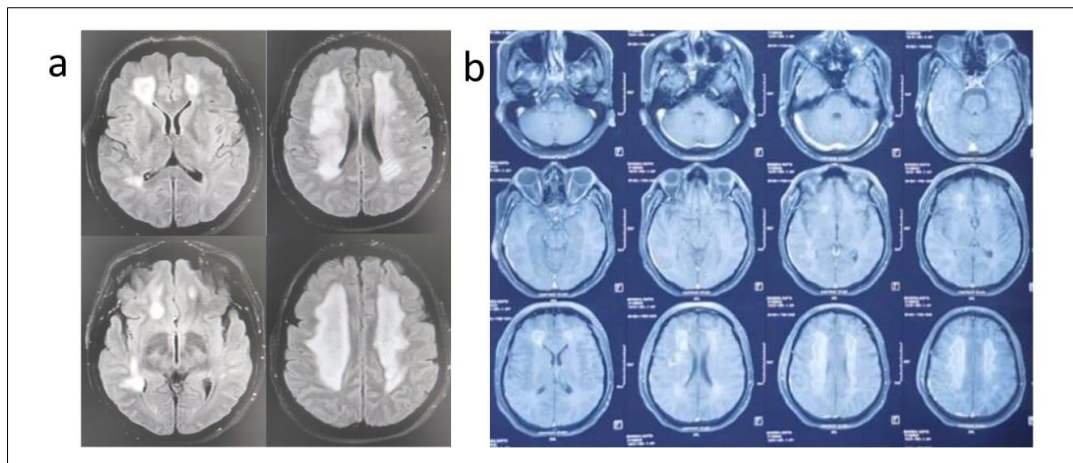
MRI T2FLAIR image (a) showing patchy infarcts in bilateral hemispheres with progressive vasogenic edema surrounding these regions and decrement of the lesions two weeks post-treatment (b)
